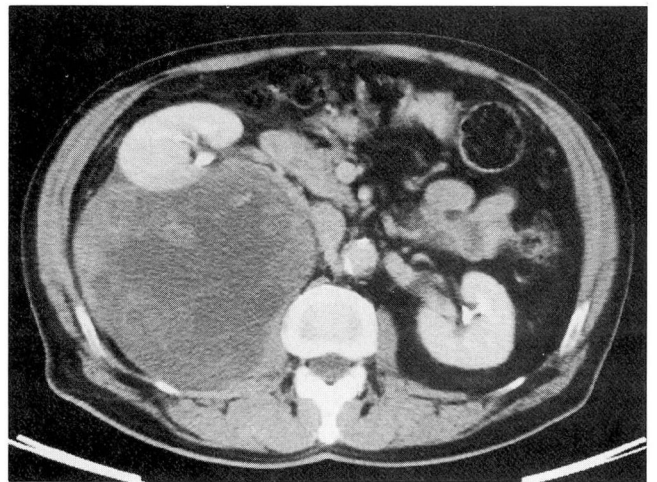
Contrast-enhanced CT shows a large heterogeneous retroperitoneal soft-tissue mass displacing the right kidney anteriorly and abutting the right psoas muscle.
